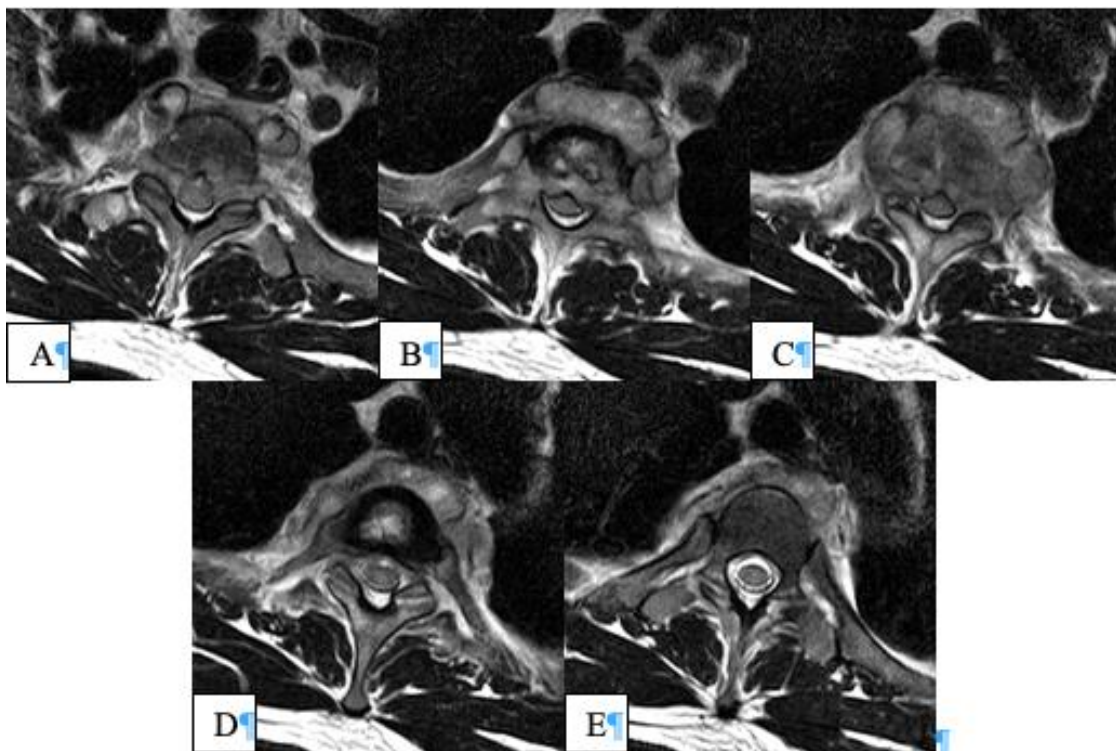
T2W Axial View of MRI at level of Th1 (A), Th1-2 (B), Th2 (C), Th2-3 (D), Th3 (E)
